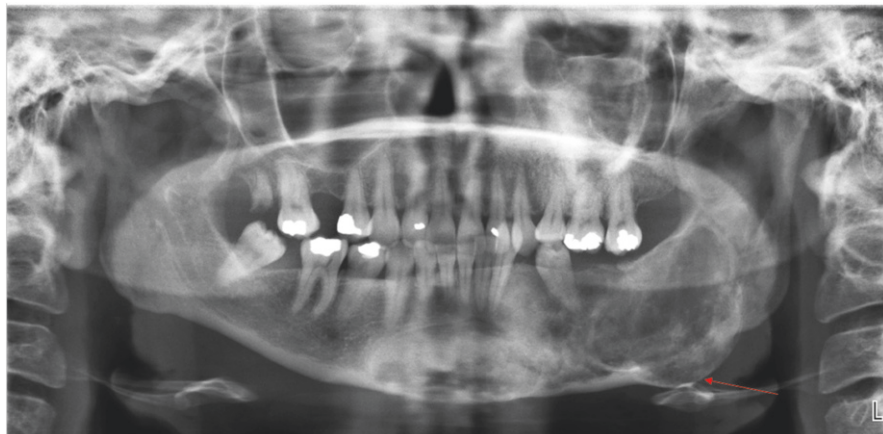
Panoramic radiograph of a 44-year-old female with fibrous dysplasia of the mandible. Multilocular, mixed lesions are seen in the left mandibular body and mandibular symphysis, with associated cortical expansion (*arrows*) (Radiograph courtesy of Leonard B. Kaban, DMD, MD)
